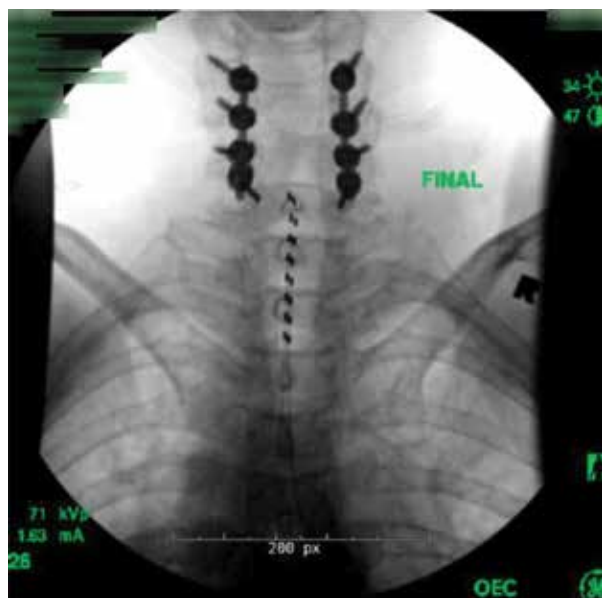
AP x-ray of the permanent spinal cord stimulation (SCS) (C7-T3) leads
